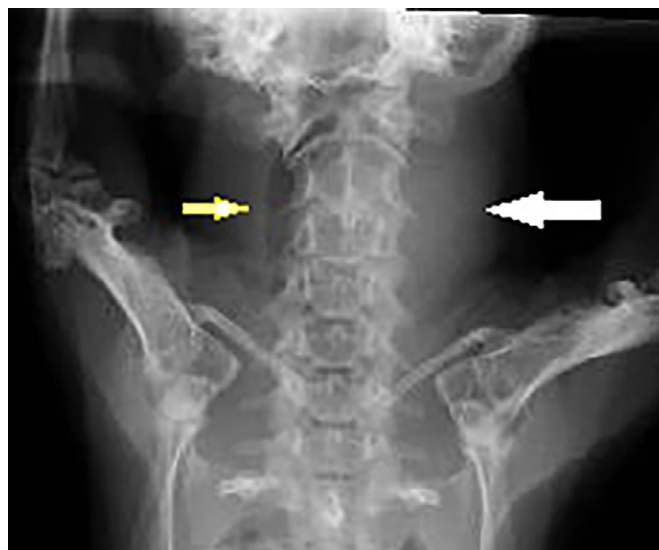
Radiograph of the dorsoventral view of the patient's thorax.
